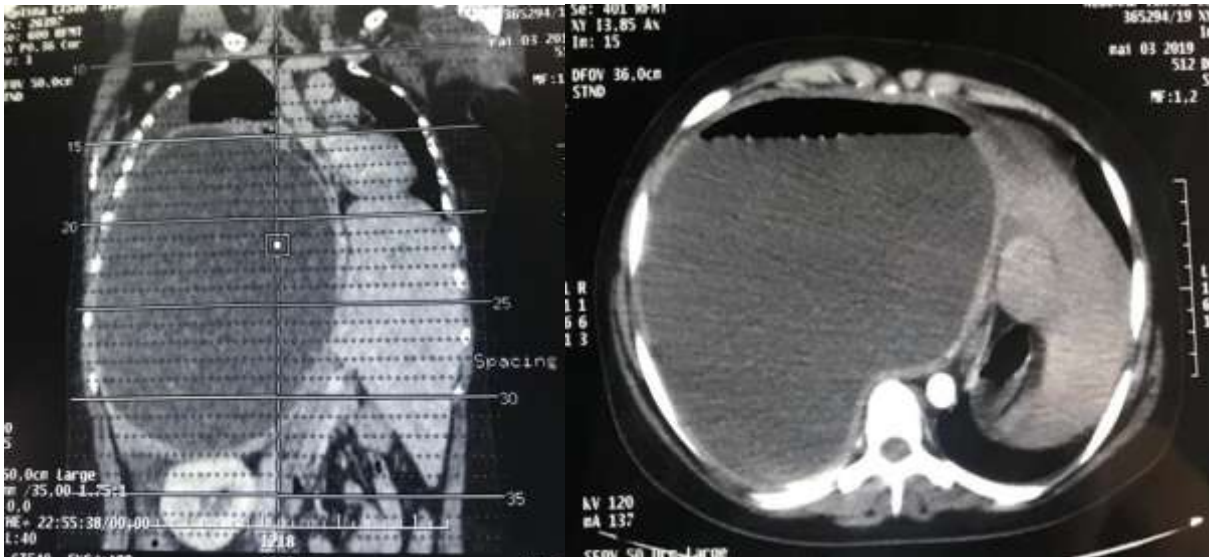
CT scan showed a large hydatid cyst in the liver.
